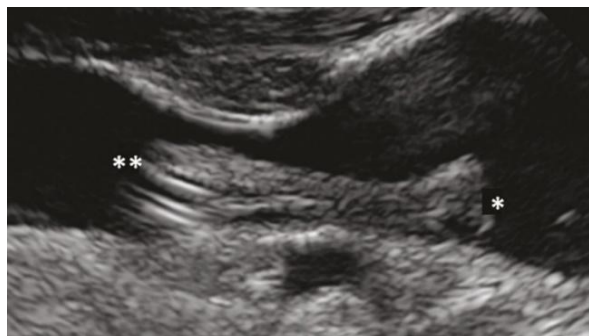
Incomplete thrombosis of the internal jugular vein on cervical Doppler ultrasound
